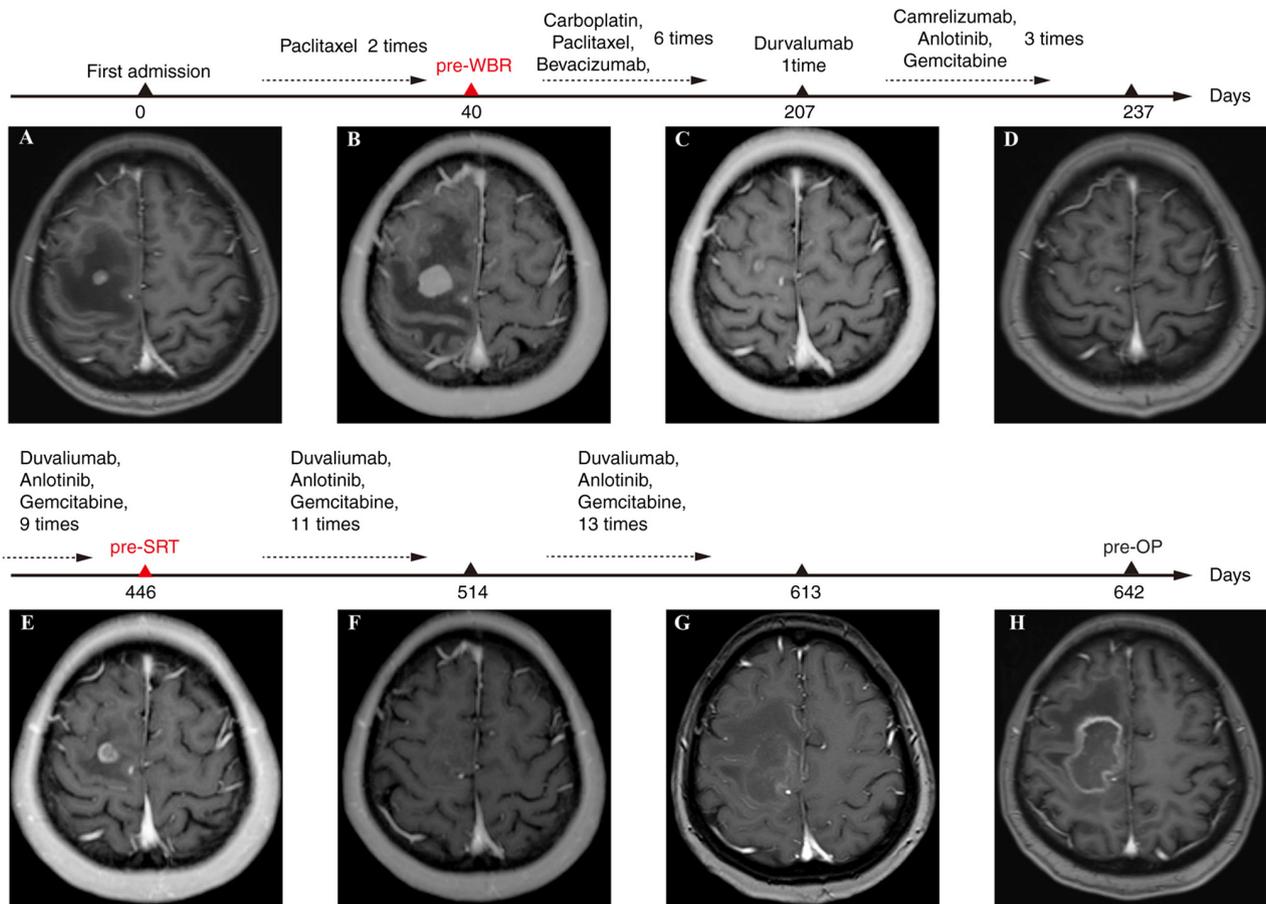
Timeline of the treatments and longitudinal enhanced MRI of intracranial lesions. (A) Enhanced MRI of right frontal metastasis at initial diagnosis. (B) Before receiving whole brain radiosurgery, the lesion was treated with paclitaxel. (C) Subsequently, the patient began bevacizumab and paclitaxel-carboplatin chemotherapy for 3 cycles and durvalumab treatment for 1 cycle. (D) Enhanced MRI of right frontal metastasis following 3 cycles of treatment with camrelizumab, anlotinib and gemcitabine. Enhanced MRI of right frontal metastasis following (E) nine, (F) 11 and (G) 13 cycles of treatment with duvaliumab, anlotinib and gemcitabine. (H) Enhanced MRI of right frontal metastasis before surgery. MRI, magnetic resonance imaging; WBR, whole brain radiosurgery; SRT, stereotactic radiotherapy; pre-OP, pre-operation.
